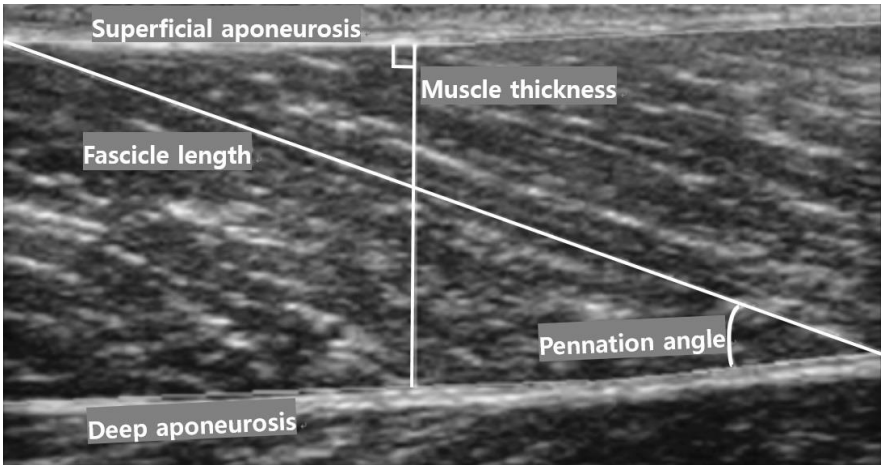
Ultrasound image showing muscle architecture parameters measured.
